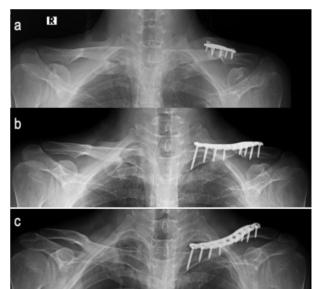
The preoperative radiograph displays a case of nonunion of the mid-shaft clavicle following initial surgical treatment. Note that loosening of the osteosynthesis with the pull-out of the screws (a). The postoperative standard radiographs show continuity of cortex as evidence of union at the nonunion site (b and c).
